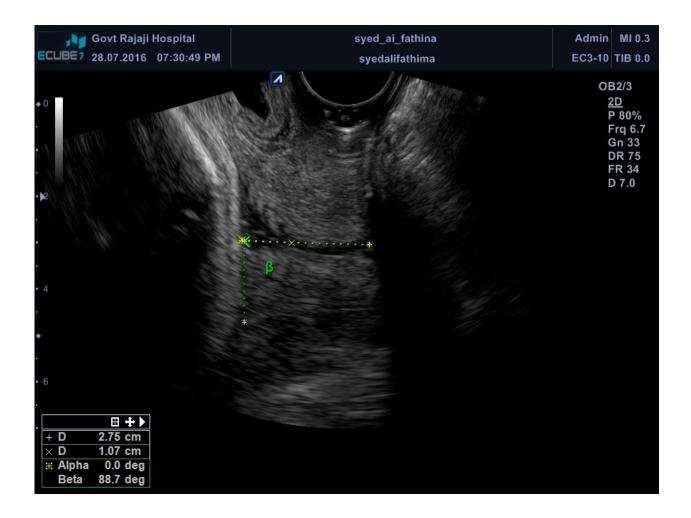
Transvaginal sonographic measurement
